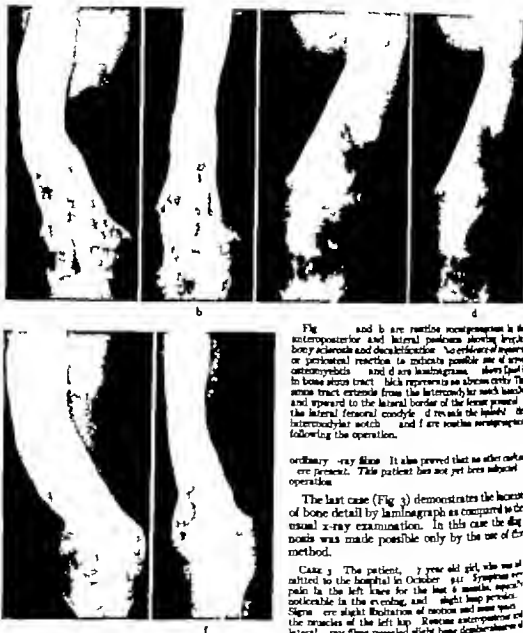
(a) and (b) are routine roentgenograms in the anteroposterior and lateral positions showing bony sclerosis and decalcification. No evidence of sequestra or periosteal reaction is indicative possible site of an osteomyelitis. (c) and (d) are laminograms, shown (a) in bone stress tract which represents an abscess cavity. The same tract extends from the intercondylar notch backward and upward to the lateral border of the femur proximal to the lateral femoral condyle. (d) reveals the location of the intercondylar notch. (e) and (f) are routine roentgenograms following the operation.
